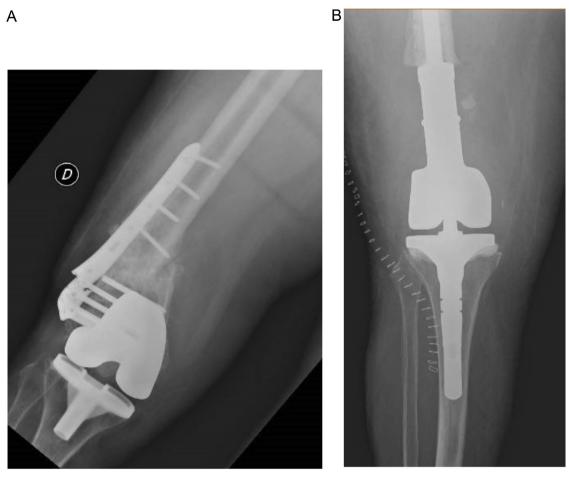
A) X-rays AP view: non union of periprosthetic fractures previously treated by plate fixation. B) x-rays AP view: megaprosthesis.
